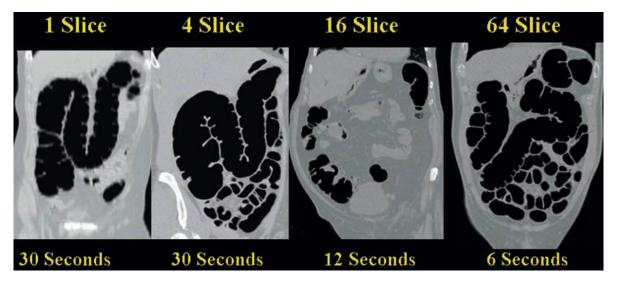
Coronal CT images reconstructed from axial data. The single slice acquisition utilized 5 mm thick sections. The resulting Z-axis resolution is poor. The 4, 16 and 64 row scanners utilized 1.25, 1, and 0.75 mm thick axial sections respectively. Note improvement in time of acquisition
